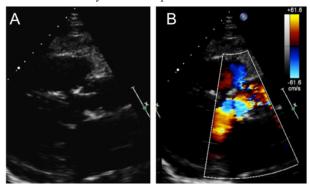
Figure I Parasternal long axis transthoracic echocardiogram (A) demonstrating thickened aortic valve leaflets with a stenotic valve on colour flow Doppler (B).
